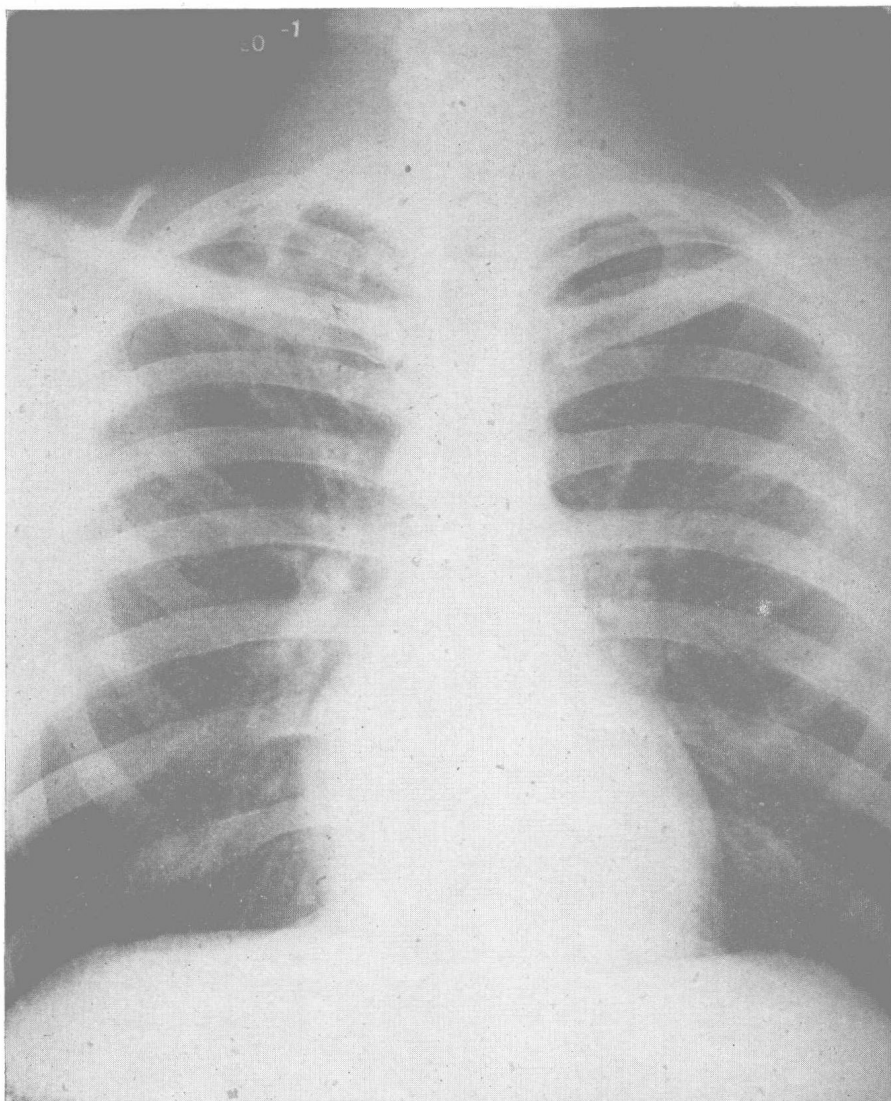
Phrenic crush and scaleniotomy. Male, age 25. Occupation, student nurse. June 1941 pleuritic pain, productive cough, sputum contained tubercle bacilli. Roentgenogram June 20, 1941, showed an infiltrating lesion of apical portion of right upper lobe with cavitation, minimum fibrosis. There was only slight improvement with bed rest and a temporary right phrenic paralysis, and a scaleniotomy was done September 3, 1941.
